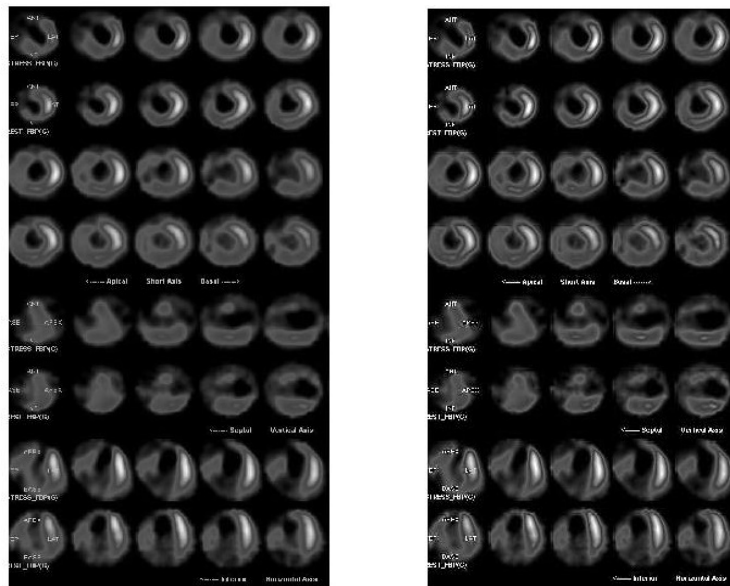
An abnormal perfusion SPECT image and SPECT image enhanced using the proposed method
